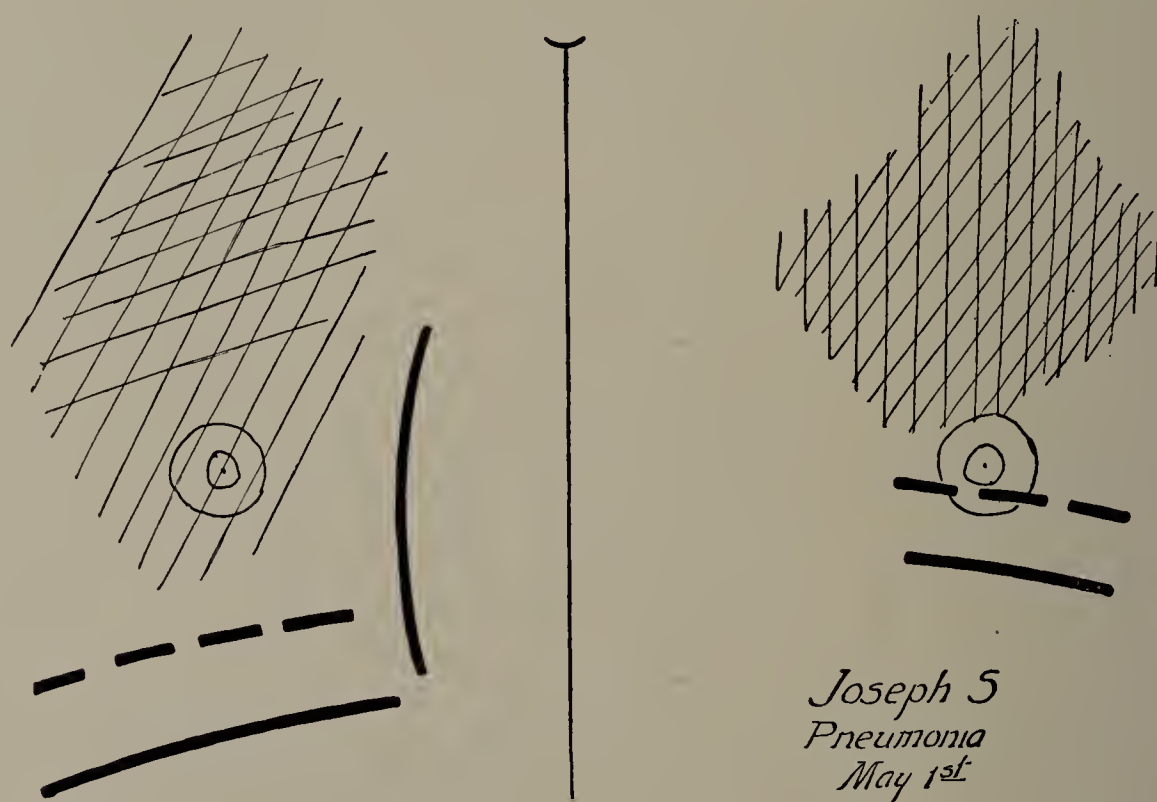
Joseph S. May 1. Pneumonia. Question of pleuritic fluid. X-ray examination with screen showed there was no fluid in either pleural sac, as the outlines of the diaphragm were clearly seen, and the shadow did not change its shape when the patient changed his position. (One-third life size.)
